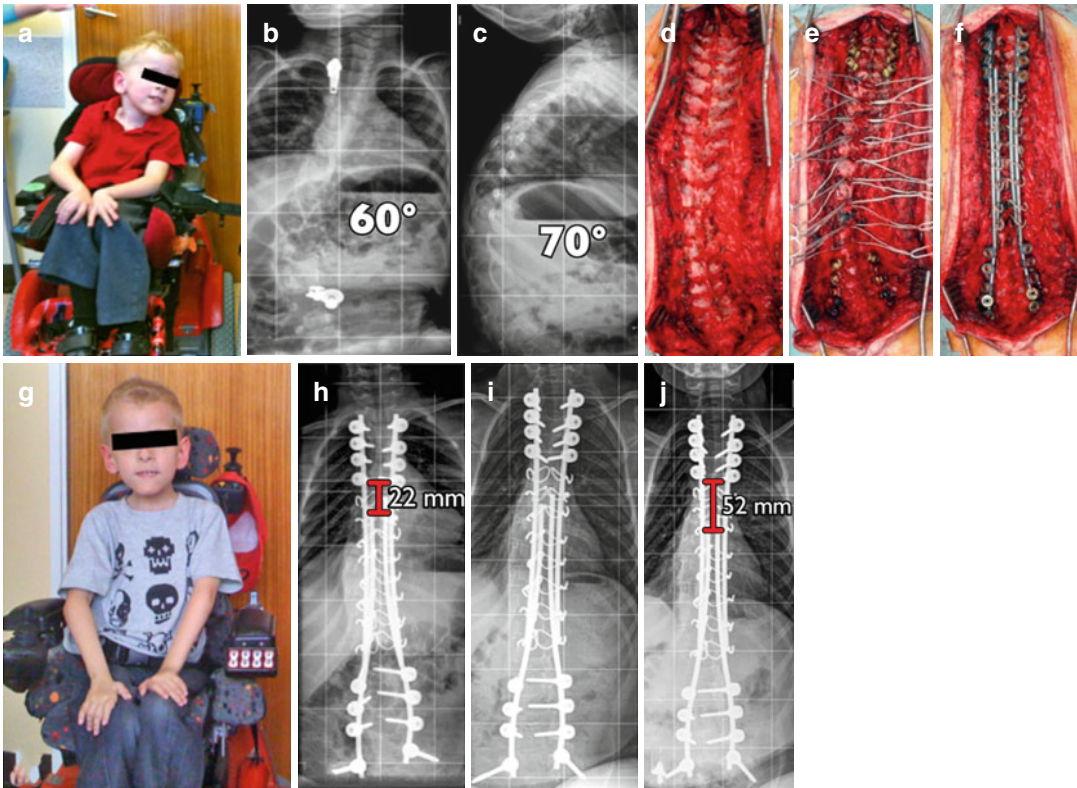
Clinical example of a self-guided growth construct as described by Mehdian et al. treating an early onset neuromuscular scoliosis in a child with spinal muscular atrophy. (a) Preoperative clinical pictures. (b, c) Sitting AP and lateral x-rays pre-op. (d) Intraoperative
